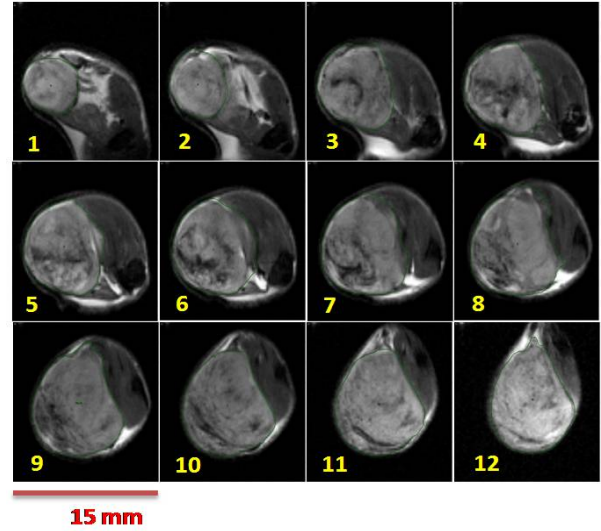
These images were obtained using spin echo (SE) pulse sequence with TR/TE = 2000/50 ms, slice thickness = 1mm, inter slice thickness 1mm, field of view (FOV) = $24 \times 24\text{mm}^2$, matrix = 128×128 , 4 averages and total measuring time 4 min. MRI tumor volume is 727mm^3 .
